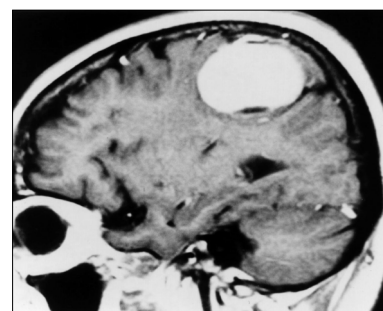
T₁-weighted sagittal image of preoperative magnetic resonance imaging shows an enhancing, extra-axial mass along the left parietal convexity.
